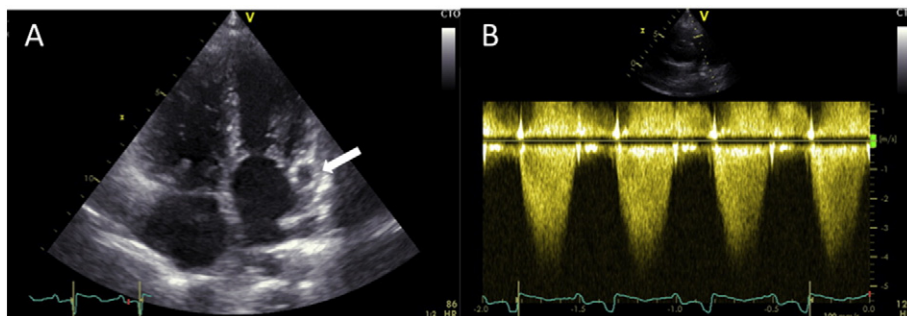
Echocardiography. A: Apical 4 chamber view showing right ventricular dilatation and circumflex artery aneurysm (arrow). B: Continuous Doppler of pulmonary valve ejection flow.
